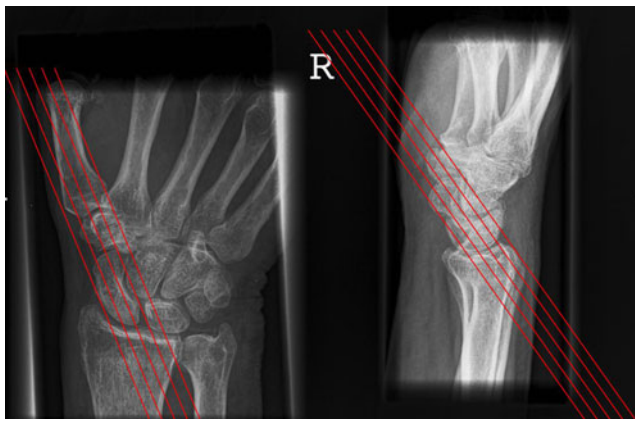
The longitudinal axis of the scaphoid on PA and lateral radiographs, respectively. The *red lines* represent the long axis of the scaphoid in which the scans are reformatted
